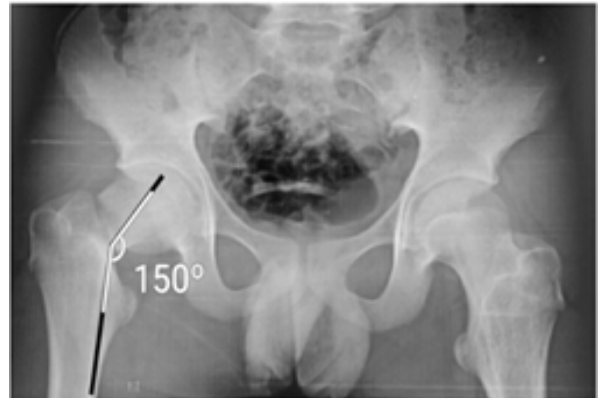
Pre-operative Xray Showing Low Transcervical, Garden Type III Fracture Right Side
